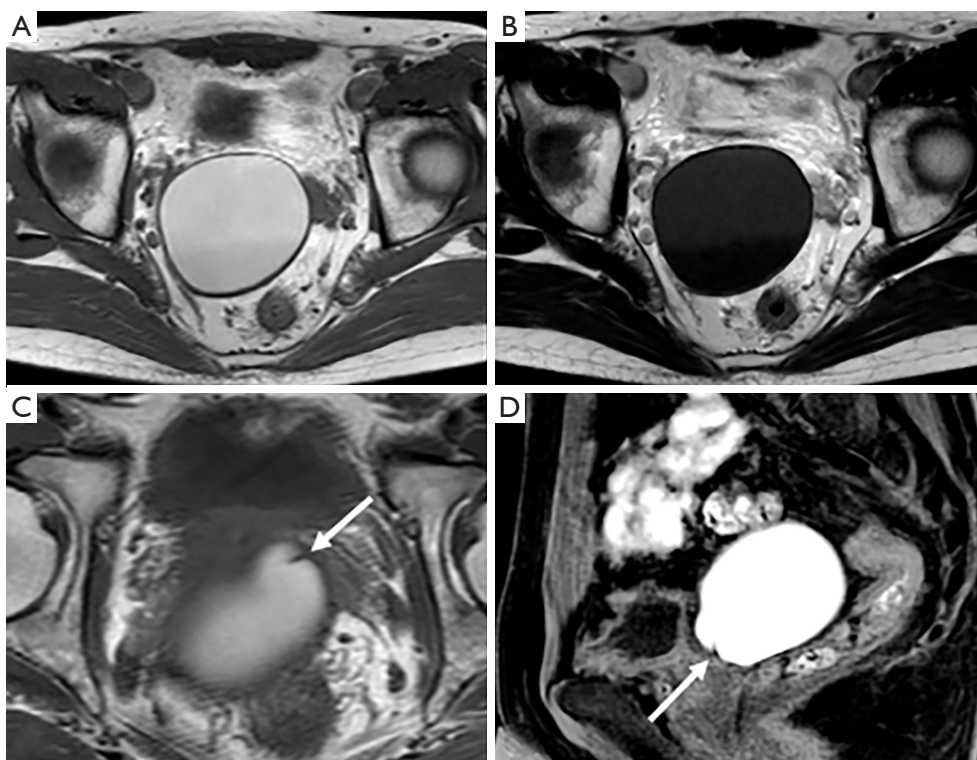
Non-enhanced pelvic magnetic resonance imaging demonstrated mass on dorsal side of bladder, which showed uniform high-intensity in T1-weighted (A) and low-intensity in T2-weighted (B) images. A wedge-shaped structure in the mass was partially visible in both axial (C) and sagittal (D) T1 images (arrows).
